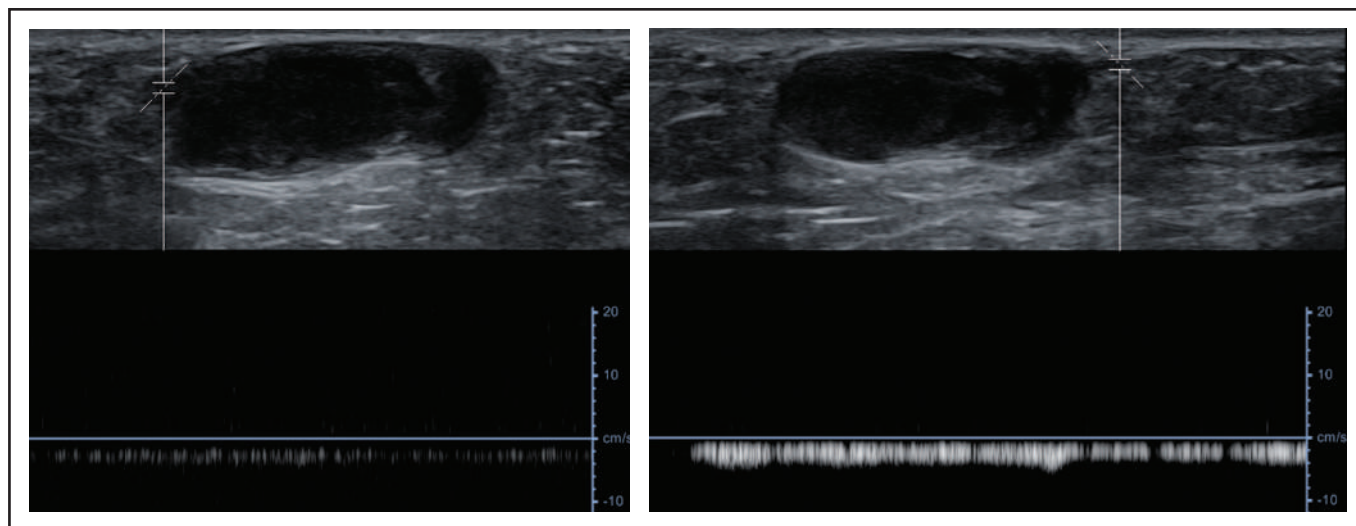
Pulsed-Wave Doppler analysis in the connection vessels. (A) The cranial vessel demonstrates venous flow waveform estimated around 3.3 cm/second. (B) The caudal vessel demonstrates venous flow waveform estimated around 4.0 cm/second.
